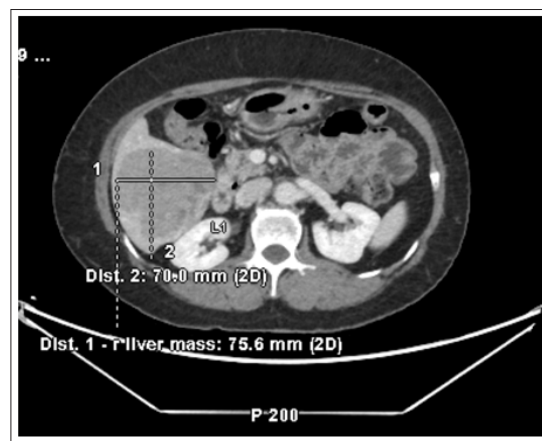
Preoperative CT scan of the primary hepatic neuroendocrine tumor. The tumor at segments V, VI and VII has an aggregate measurement of approximately 7.6 x 7 x 7.1 cm. The findings were compatible with malignancy
